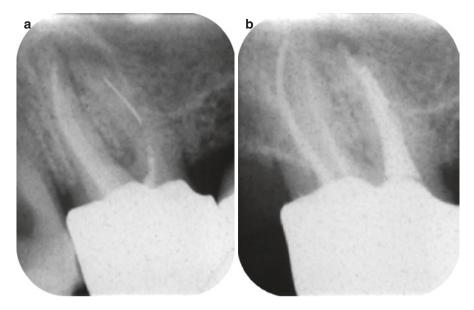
(a) Preoperative radiograph showing a fractured instrument in the mesiobuccal root canal of a maxillary molar. (b) During successful removal of the fragment, a second instrument (Hedstrom file) fractured. Despite this second fracture, the root canal could be prepared and obturated to its apical terminus
